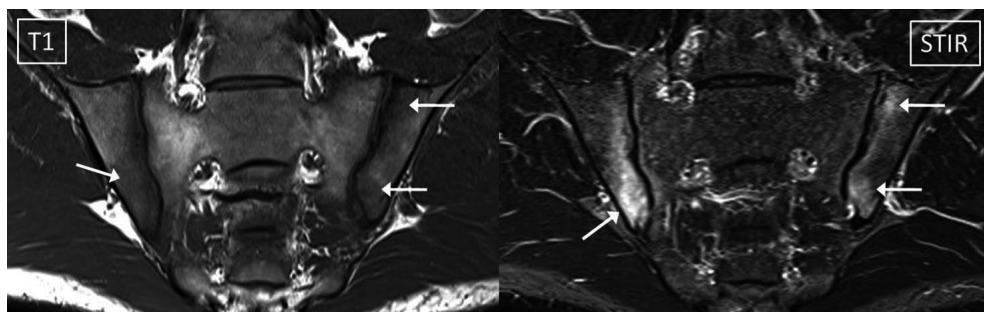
MRI sacroiliac (SI) joints—typical inflammatory sacroiliitis in non-radiographic axial spondyloarthritis. MRI of SI joints in a 26-year-old male with inflammatory low back pain of more than 3 months duration. C-reactive protein was 49.3 mg/L and HLA-B27 was positive. Pelvic radiograph was suspicious for spondyloarthritis but did not meet the definition for a positive radiograph according to the modified New York criteria—right SI joint grade 1 and left SI joint grade 0. The short tau inversion recovery (STIR) sequence shows abnormal increased signal (arrows) in the iliac bones bilaterally, typical for bone marrow oedema (BMO) due to inflammatory sacroiliitis. All the BMO are subchondral in location; the BMO is multifocal; each lesion is of a significant size; their margins are poorly defined; the right lower iliac lesion is larger and part of this lesion is intensely bright, similar in signal intensity to cerebrospinal fluid (not shown); and there are corresponding areas of diminished signal intensity on the T1-weighted sequence (arrows on T1). No erosion or other evidence of structural damage was visible on MRI or radiography. All these features are typical for inflammatory sacroiliitis.
